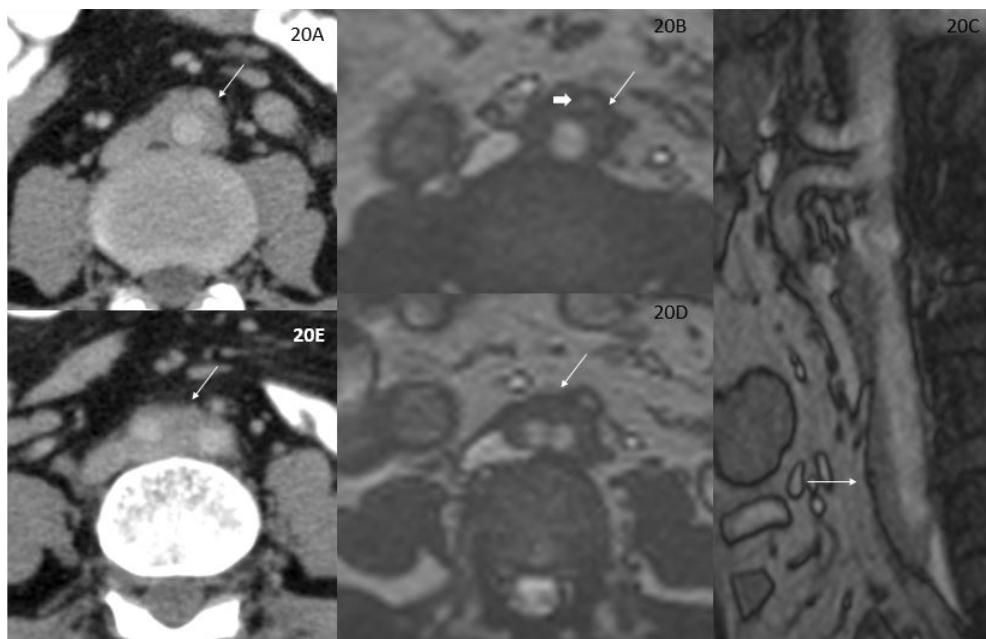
Case 5. A, E) Computed tomography image showing soft tissue thickening (indicated by white arrow) along abdominal aorta. B, C, D) Axial and sagittal T2W image showing soft tissue thickening (indicated by white arrow) along abdominal aorta with encasement of inferior mesenteric artery shown by a thick arrow
